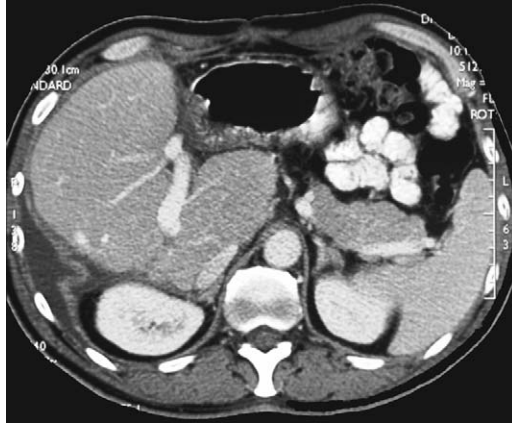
Abdominal CT scan after second-stage hepatectomy (right hepatectomy). The remnant liver parenchyma consisted of hypertrophied segments 1 and 4.
